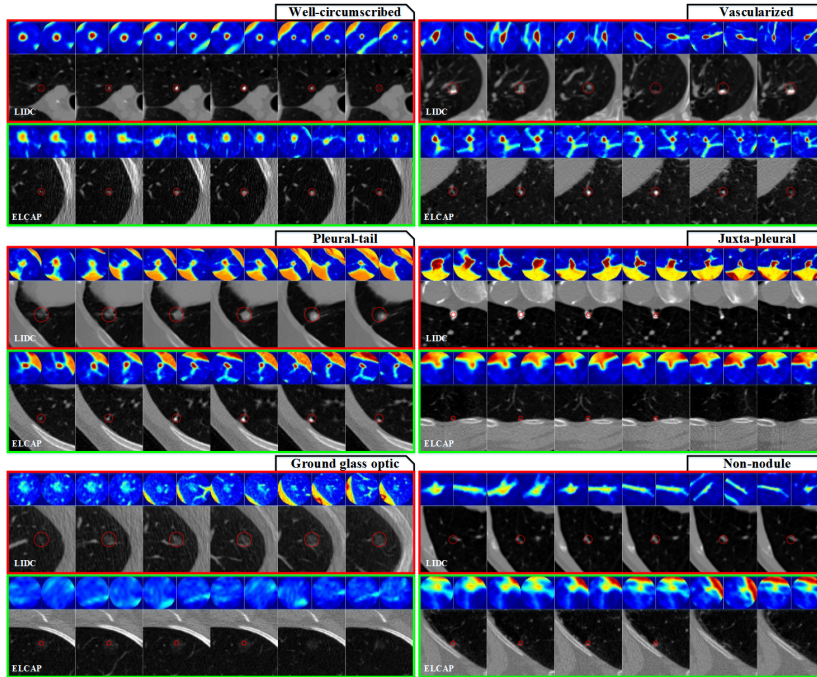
Classification results for typical cases of each type. Classified types are labeled. Red rectangles: data from LIDC-IDRI. Green rectangles: data from ELCAP. In each rectangle, top row: re-built images with color projection; bottom row: original CT images on axial plane with nodule radius labeled in red circles.
